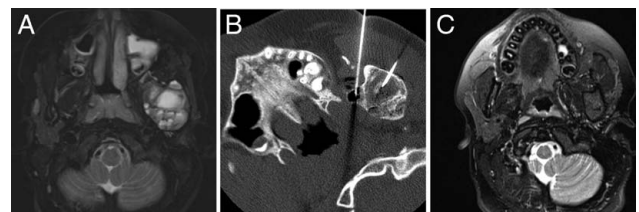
Case 3: 10-year-old girl with left mandibular ABC recurrence following 2 prior surgeries. (A) Axial T2W MR image shows ABC recurrence in the bone graft reconstruction of the left hemi-mandible. (B) Axial CT image during the third treatment shows 2 needles injecting different loculations. (C) Axial T2W MR image at 2.5-year follow-up showing resolution of the ABC. ABC indicates aneurysmal bone cyst; CT, computed tomography; MR, magnetic resonance.
